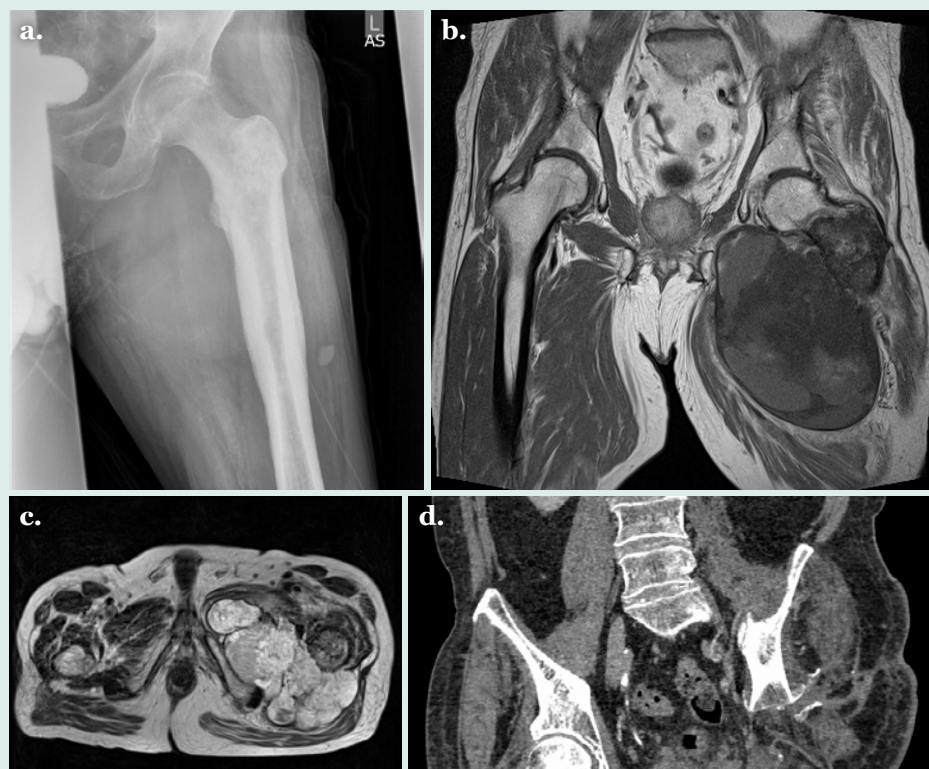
74 year old male, dedifferentiated chondrosarcoma of proximal femur. AP radiograph (a), coronal (b) and sagittal (c) MRI scans highlight the large soft tissue mass and bone involvement, and the postop film (d) following a hindquarter amputation for tumour clearance.
